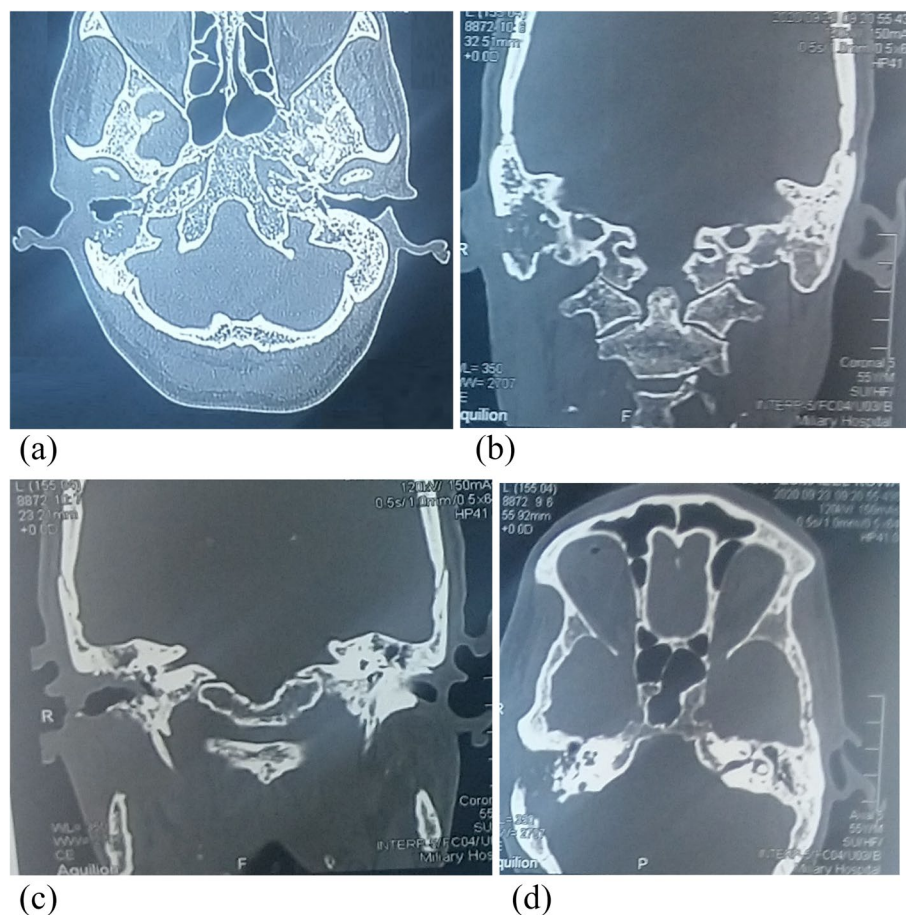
HRCT–temporal bone–axial and coronal cuts show the automastoidectomy cavity with the destruction of all the air cells boundaries on the right side and erosion of the posterior wall of the right EAC. Courtesy of Dr. Fatima Ayed Akoud – ENT Registrar Sudan Medical Specializations Board
